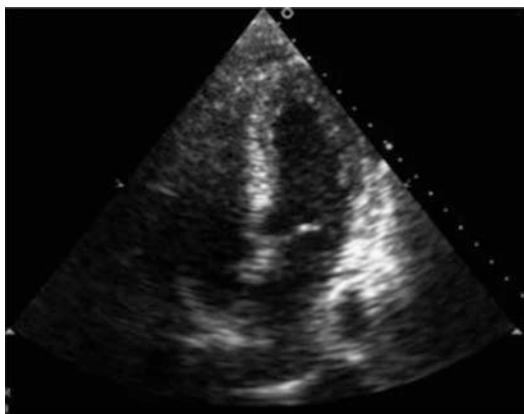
ECO transthoracic (EF, 15%)
